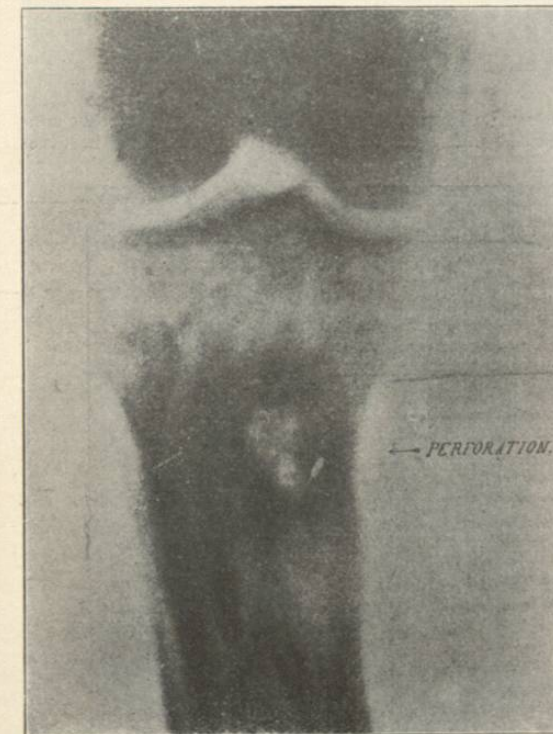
Radiograph. In case of W. K.—, showing perforation of upper end of tibia. Wounded June 25th, 1899, by a Krag-Jørgensen bullet at a distance of 10 feet. The fracture extended up into the knee joint, as shown by the escape of synovial fluid after injury. Radiograph taken six months after injury. Remote effects: slight weakness and pain at site of wound.
